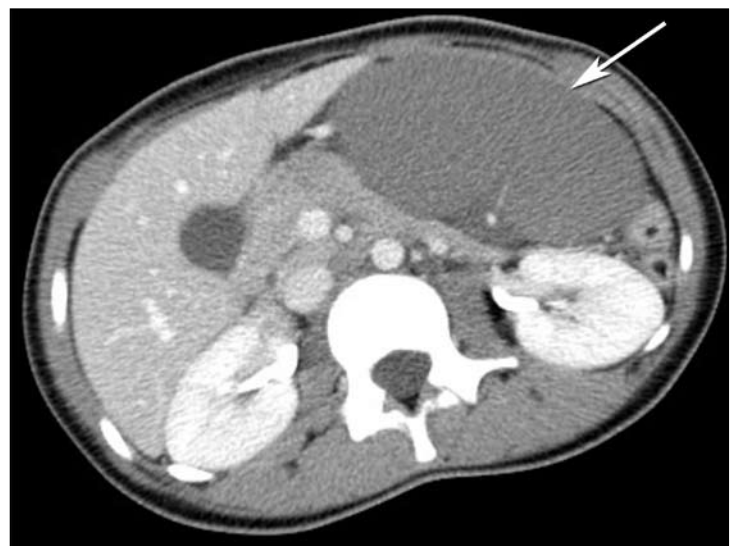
Computed Tomography. Coronal image. (left) Ectopic spleen (arrow) without parenchymal enhancement. Axial image. (right) Ectopic spleen (arrow) anterior to left kidney and pancreas.
